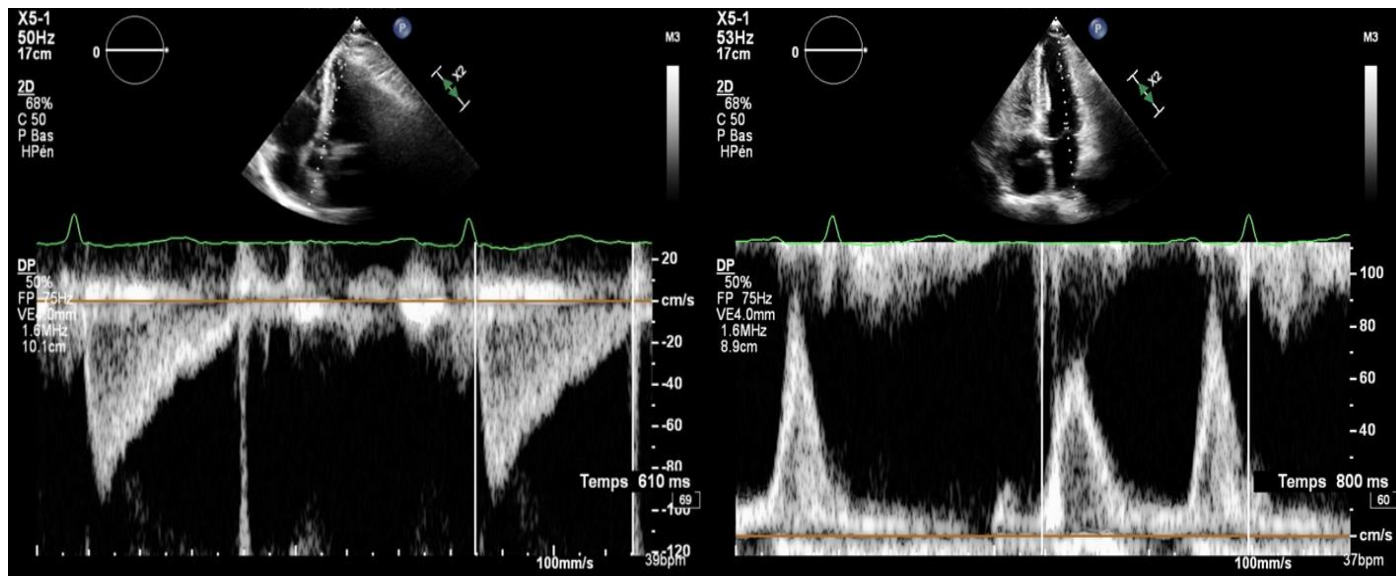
Pulsed wave Doppler through aortic and mitral valves: prolonged left ventricular ejection time (610 ms) and shortened left ventricular filling time (800 ms).
